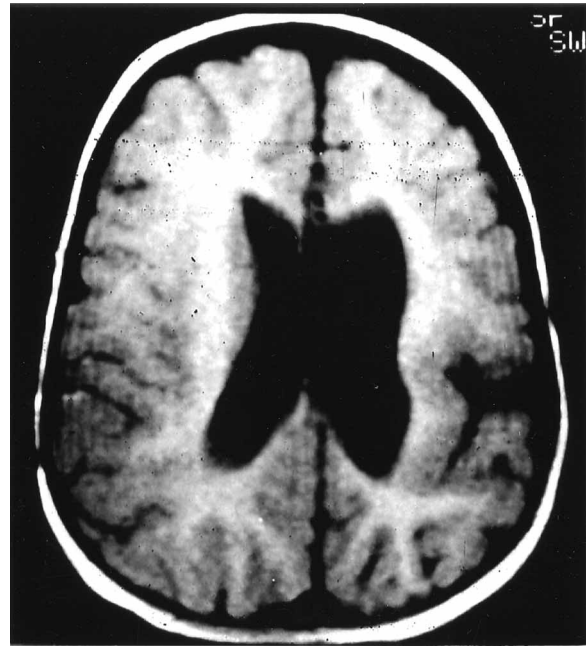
MRI patient 9: aspect of unilateral perisylvian dysplasia: the left sylvian fissure is enlarged and bordered by a thick cortex devoid of interdigitations with white matter (axial T1 sequence).
